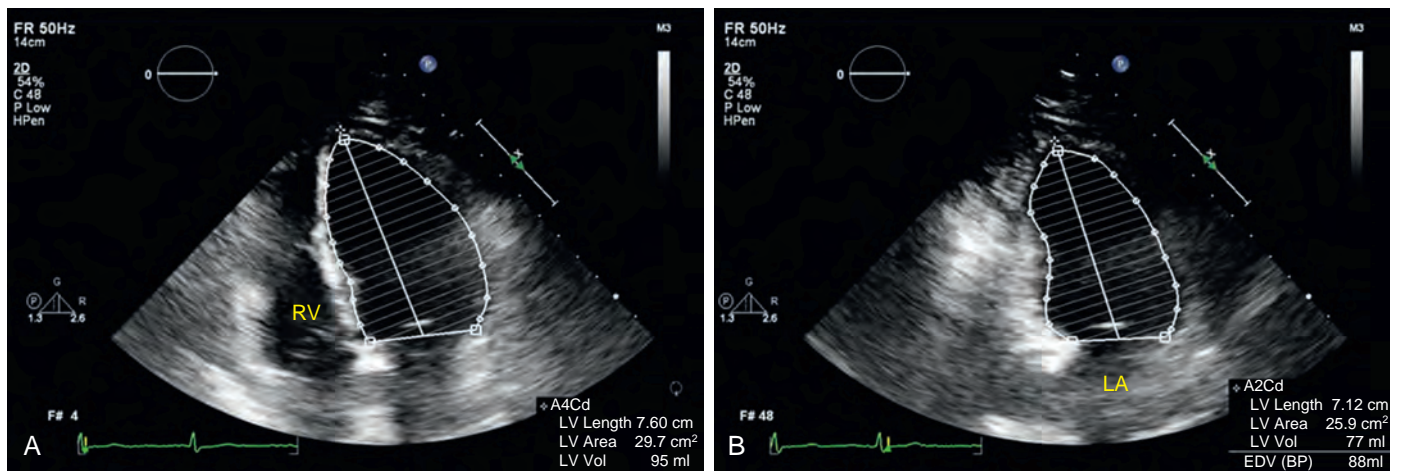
Measurement of left ventricular volumes and ejection fraction using the Simpson summation-of-disks method. A, Apical four-chamber view in end-diastole. B, Same view in end-systole. LA, Left atrium; RV, right ventricle.
